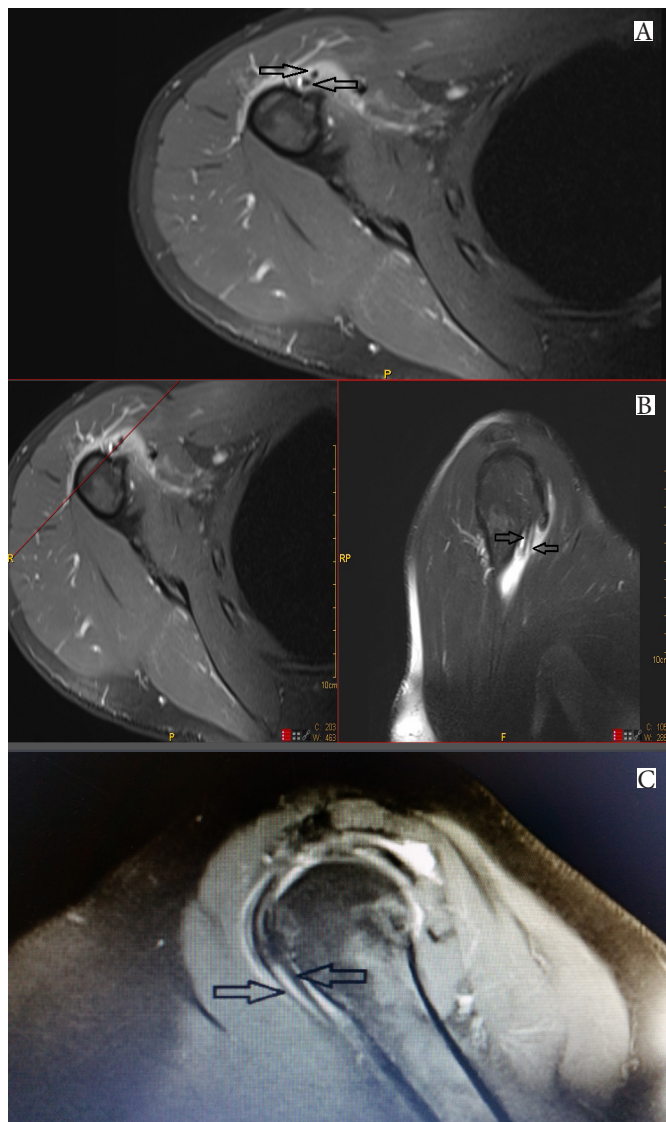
MRI shows duplication at the level of bicipital groove in T2 axial (a), coronal (b), and sagittal (c) sections
